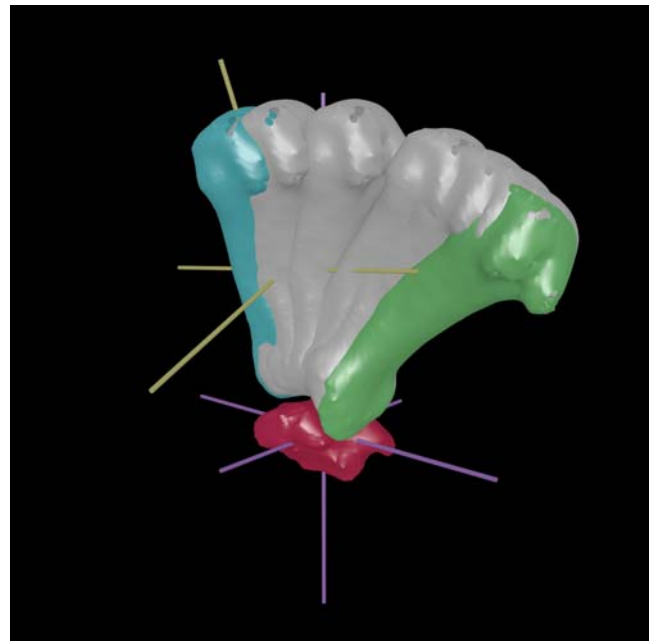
Reconstruction of 4D CT with metacarpal and trapezium axes during opposition movement of the thumb
